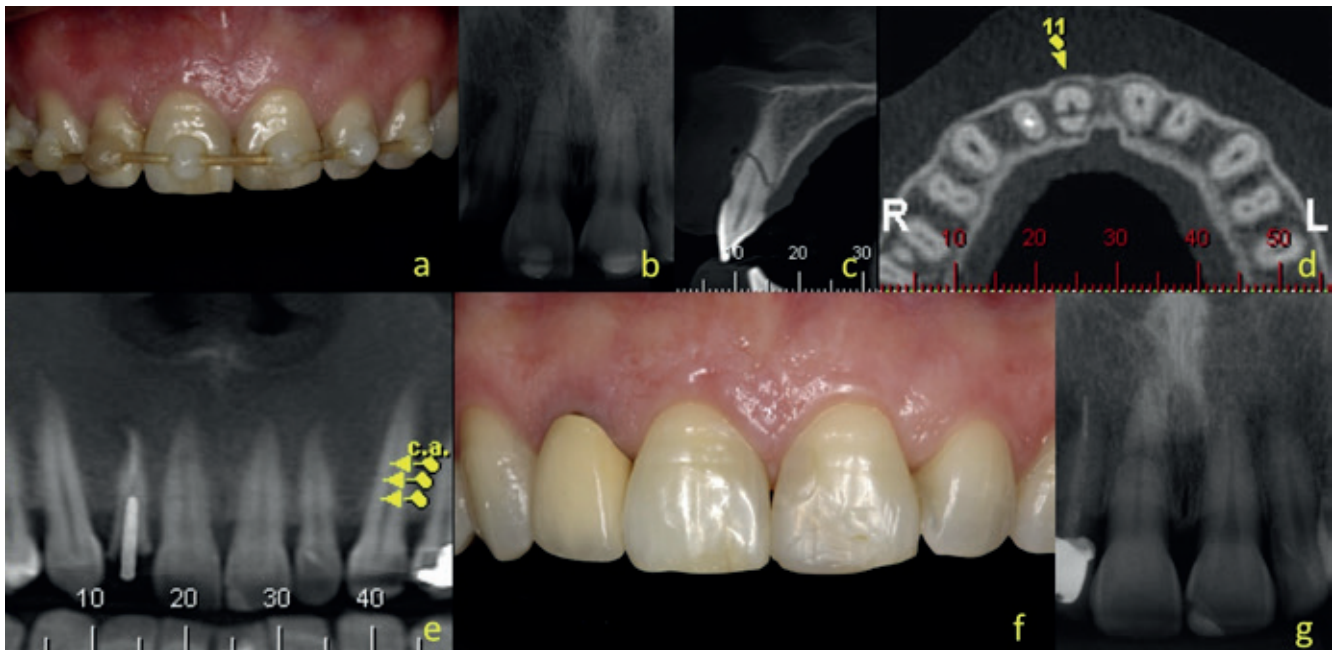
(a) Image obtained 10 days after the trauma. (b) Periapical radiograph suggesting root fracture at the apical third of the right maxillary central incisor. (c) CBCT showing the sagittal. (d) axial (e) and panoramic view. (f) 2-year follow-up evidencing healthy clinical appearance. (g) Periapical radiograph at 2-year follow-up displays healing of the horizontal root fracture.
